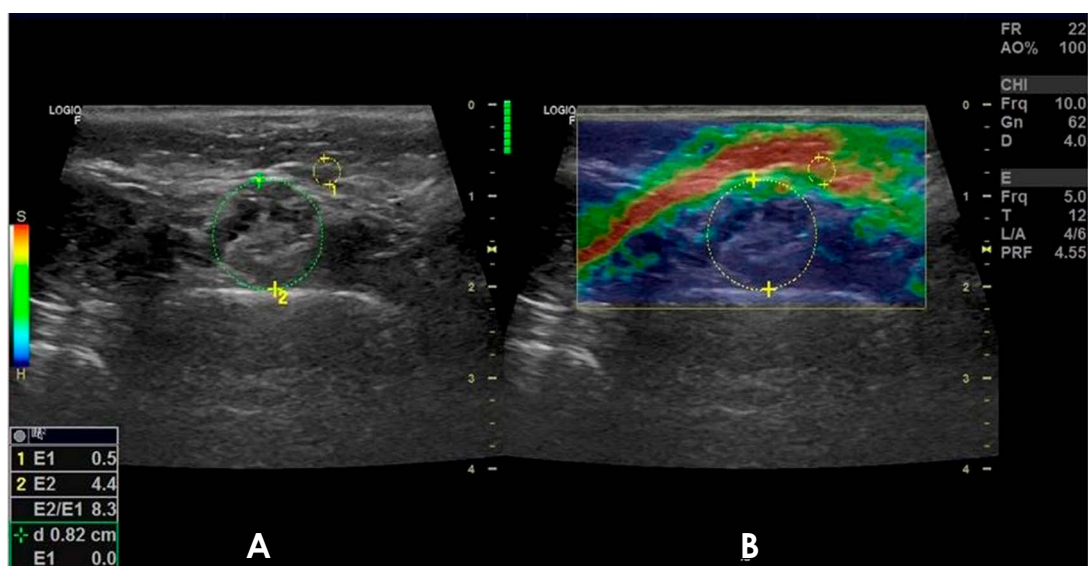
The masseter muscle elasticity index (EI) value was calculated as the ratio of the average EI of the masseter muscle in the bite position to the average EI of the subcutaneous adipose tissue (indicated by the small circle) of the masseter muscle (indicated by the large circle). A. A normal ultrasound image of the masseter muscle. B. An ultrasound elastography image of the same masseter muscle as shown in image A, depicted in the bite position.
